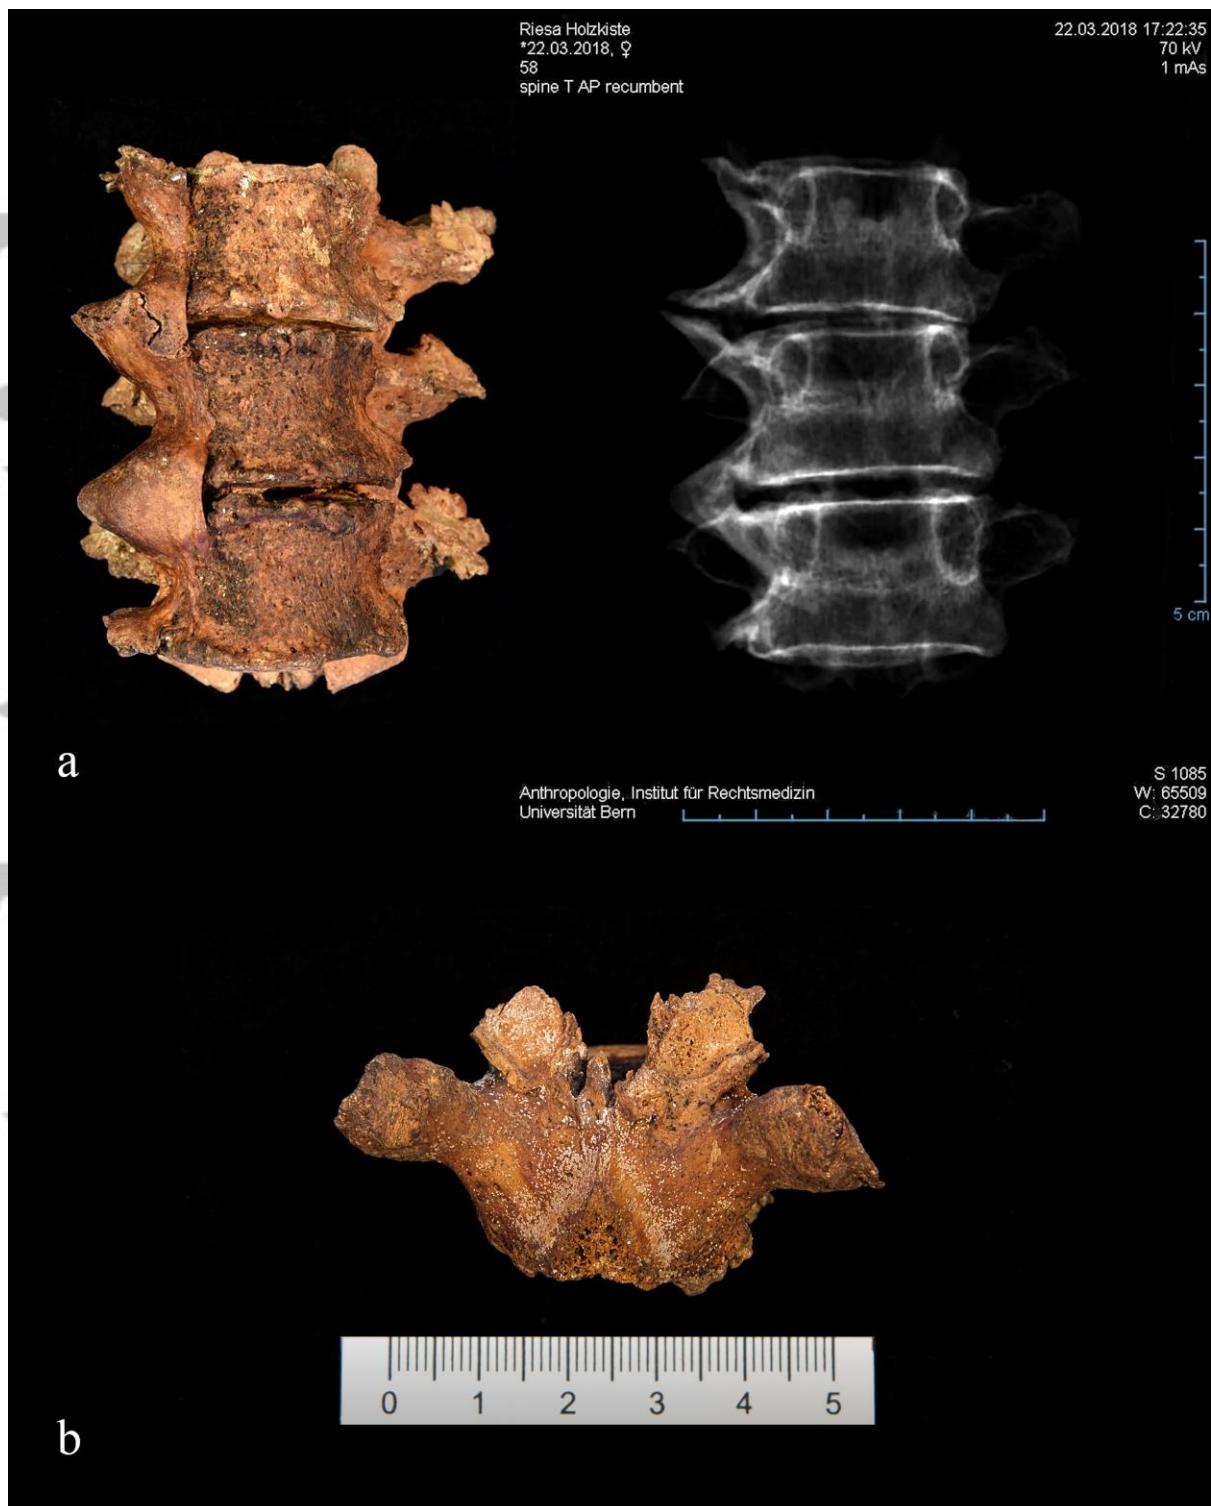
Overview a) Anterior photograph and radiographic image of T6 to T8, showing the candlewax like ossification on the right side of the vertebrae and ossification of costovertebral cartilage. Detail b) the posterior view of a thoracic vertebra with subchondral pitting and osteophytes in the superior articular facets.
